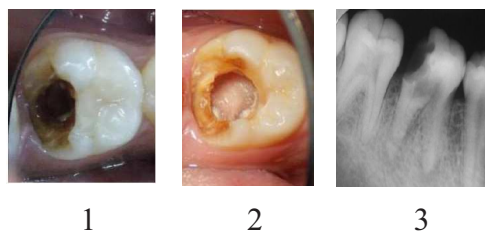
Clinical examination revealed a cavity on the disto-occlusal surface of tooth #36. Figure 2. After access opening. Figure 3. Periapical radiograph
